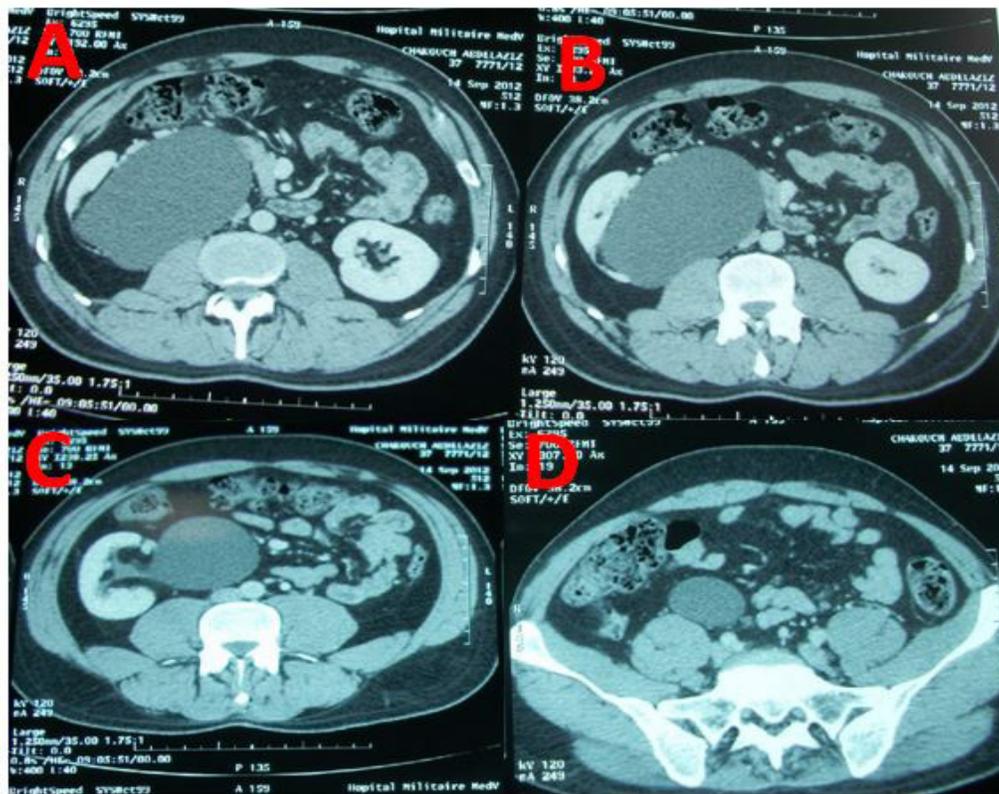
(A,B,C,D) . CT showing the kystic aspect of dilation at different levels to the iliac fossa.
